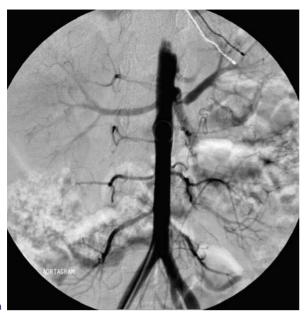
A 9-year-old, 26.6-kg male with type 1 neurofibromatosis and a past medical history of a left optic nerve glioma. Hypertension (140/100) discovered during a routine school screening examination. Medical therapy inadequately controlled blood pressure. Three days before referral to the interventional radiology service, a diagnosis of renal artery stenosis (RAS) was suggested near the origin of the left renal artery demonstrated on abdominal CT with CT angiography. a Pre-treatment imaging included abdominal aortography and bilateral renal arteriography confirming severe stenosis at the origin of the left renal artery with associated post-stenotic dilatation. b Prior to PTRA an intravenous heparin bolus of 2,000 IU was given. PTRA was attempted using 3- and 4-mm high-atmosphere (15 ATM) balloons without success. A residual pressure gradient of 45 mmHg remained. A 4×10-mm cutting balloon (Interventional Technologies, San Diego, CA) was positioned across the lesion and the balloon was inflated to approximately 6 ATM. A follow-up arteriogram (not shown) revealed mild residual stenosis. Therefore, a PTRA using a 5×2-cm balloon was performed. An arteriogram after angioplasty showed no significant residual stenosis, and the systolic pressure gradient was now less than 15 mmHg. The patient is normotensive on no anti-hypertensive medications 2 years and 9 months after treatment
